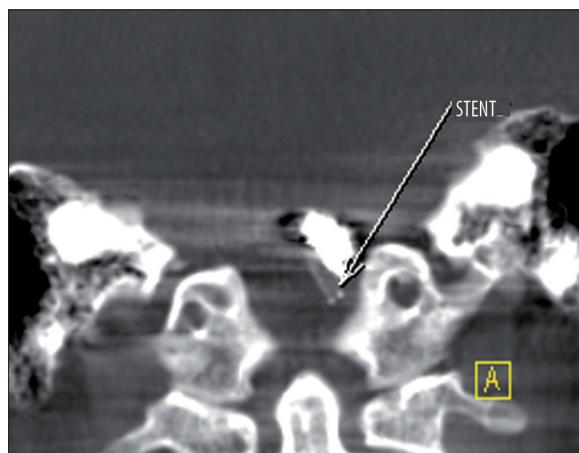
Dyna CT – MPR reconstruction, vertebral artery aneurysm after stent-assisted coiling.
